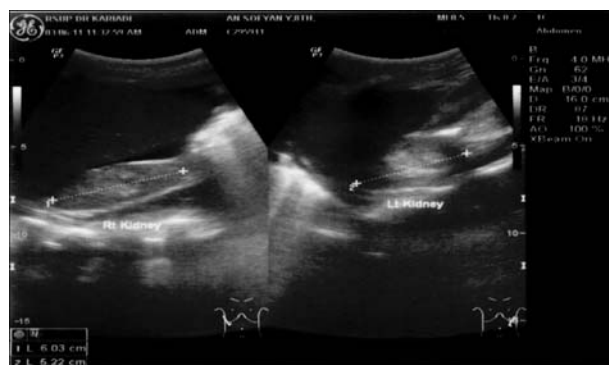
Ultrasound of kidneys showing small size and loss of corticomedullary differentiation.
